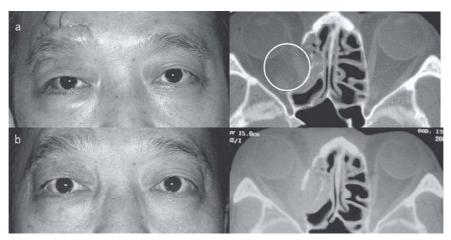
A 53-year-old man fell and hit his right eye region on a stake while playing tennis. A CT scan revealed displacement of the right inferomedial wall, and the size of the orbital wall displacement fitted the size of the globe exactly (shown as circle in a). After a bone graft operation, the enophthalmos showed good improvement (b).
